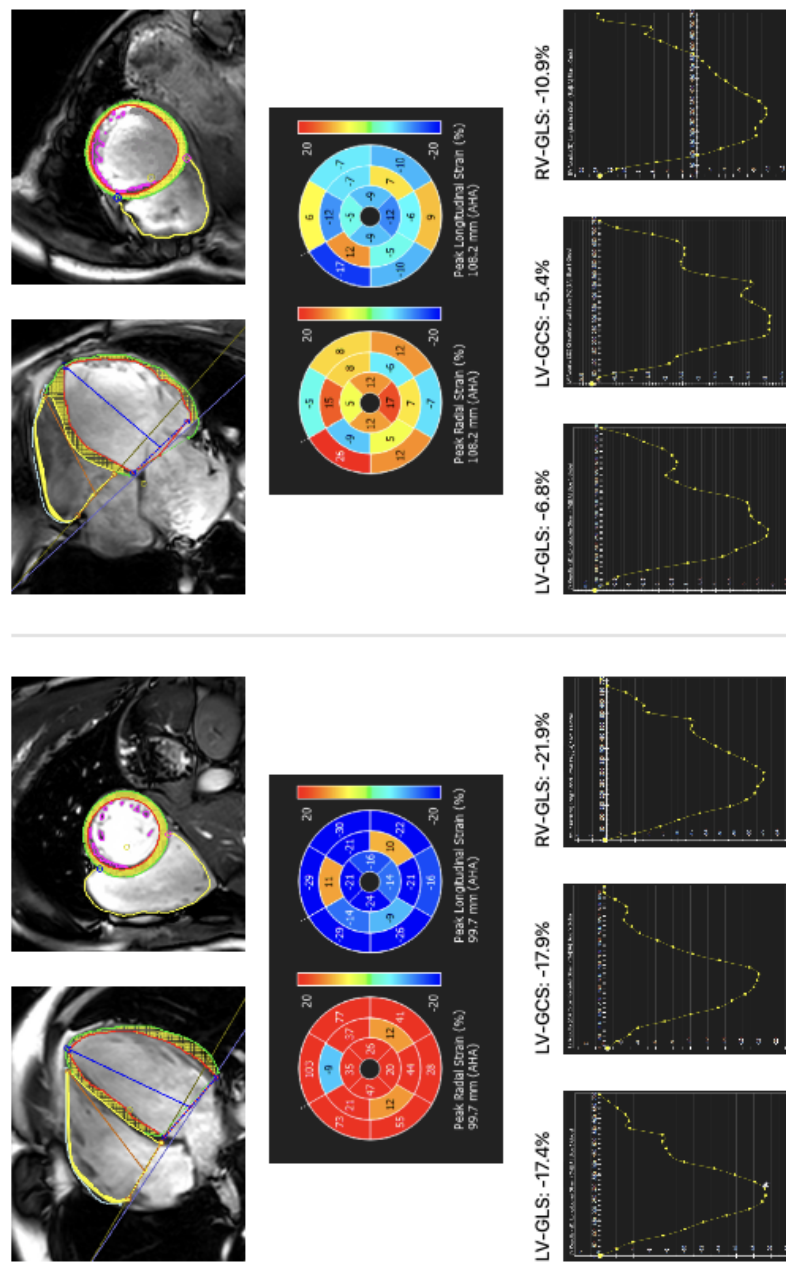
Example of speckle tracking echocardiography and cardiac magnetic feature tracking assessment. Graphs are not scaled to same data range.
